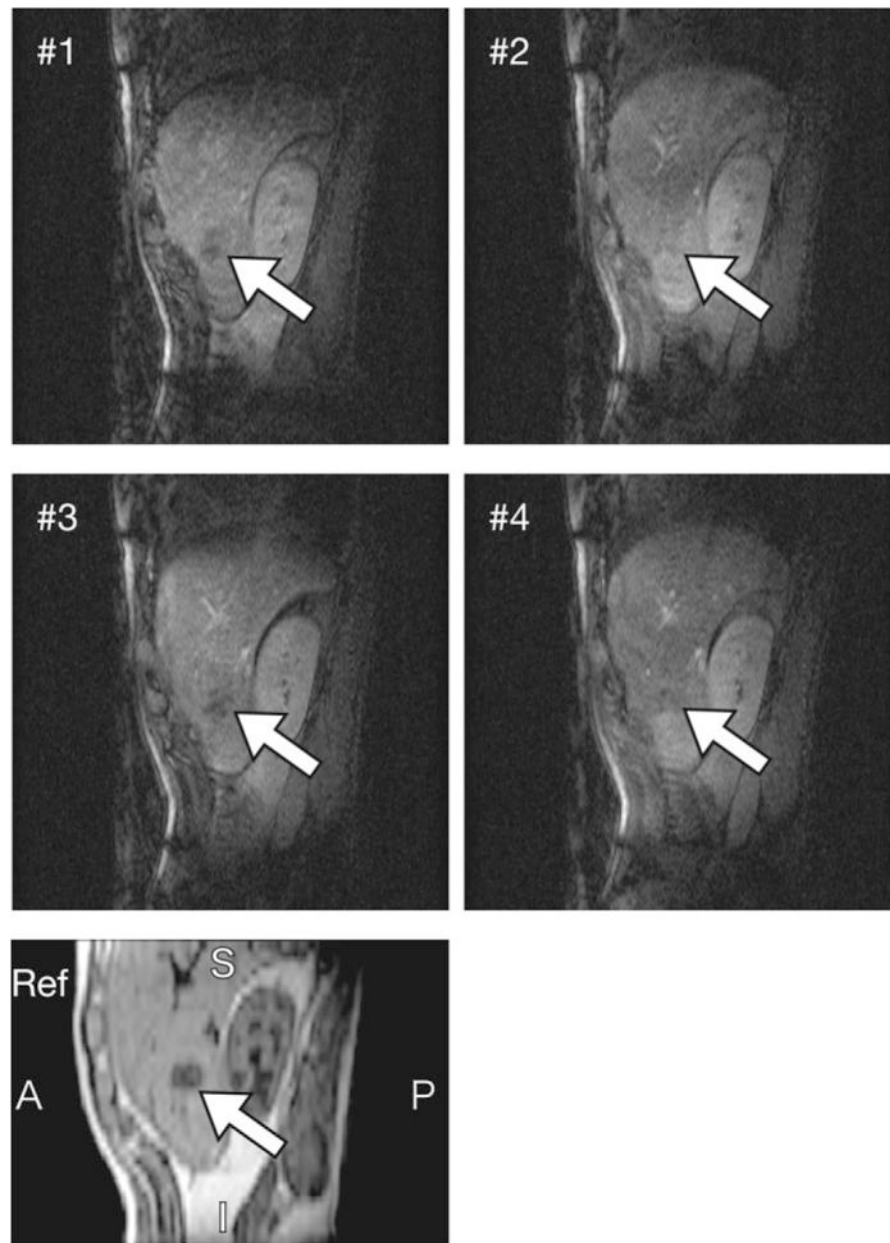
Subset of intraoperative 4D images of the patient, acquired during MRI-guided microwave coagulation therapy under general anesthesia. 2D images showing the liver tumor at four different respiratory phases are shown, with the tumor indicated in each image. In addition, part of a breath-holding 3D image is shown below as a reference.
